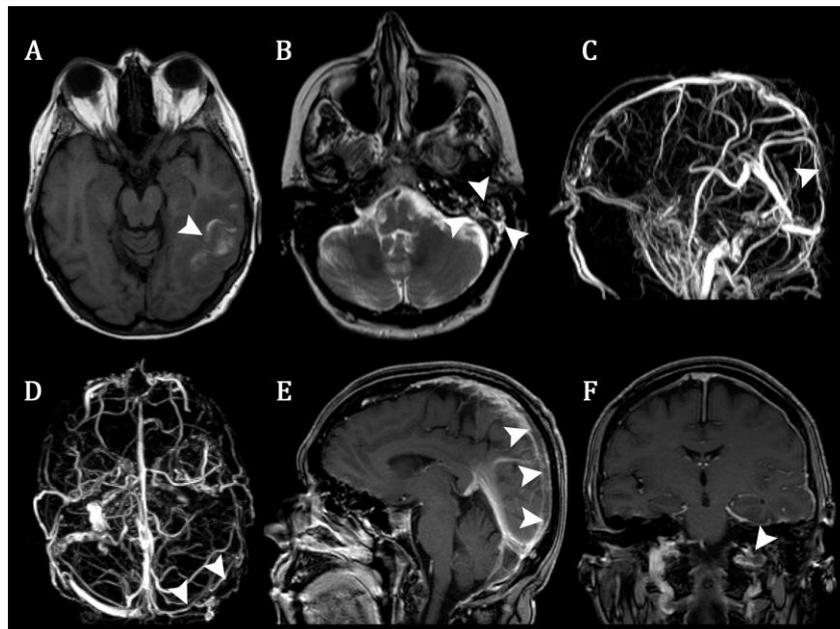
MR Imaging of the brain showing: (a) on axial T1-weighted imaging, an inhomogeneous haemorrhagic lesion in the left posterior temporal region; (b) on axial T2-weighted imaging, left mastoid fluid-filled cells. Unenhanced MR-venography (Phase Contrast technique) and Maximum Intensity Projection (MIP) reconstructions, showing: (c) (e) partial thrombosis of the superior sagittal sinus; (d) complete thrombosis of the left transverse sinus; (f) thrombosis of the left sigmoid sinus and jugular vein.
